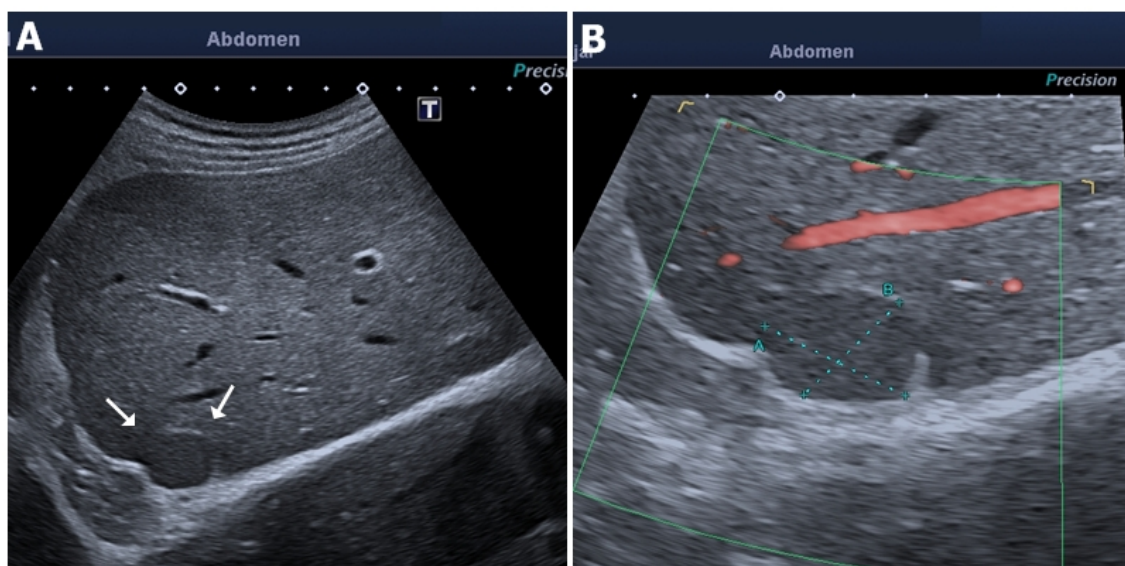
A. Isolated peripheral solid lesion of the liver, slightly hypoechoic respect to the liver parenchyma. In its most anterior portion, a thin hyperechogenic capsule can be seen that delimits it from the rest of the liver parenchyma. B. Higher magnification image, lesion of 21 x 18 mm in size. No internal vascularity was detected on Doppler ultrasonography.
